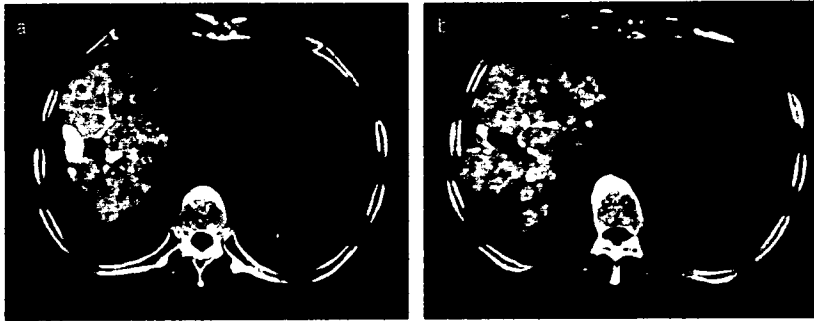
(a, b) Enhanced computed tomography images of recurrent HCC in a 63-year-old man. At the time of evaluation of recurrent HCC, many small, viable HCC nodules were mixed with tumor tissue necrotized by radiofrequency ablation and tumors retaining lipiodol after transcatheter arterial chemoembolization. Of the three tumor markers, only alfa-fetoprotein showed increased levels at the time of this imaging examination. This patient has survived for more than 4 years.
